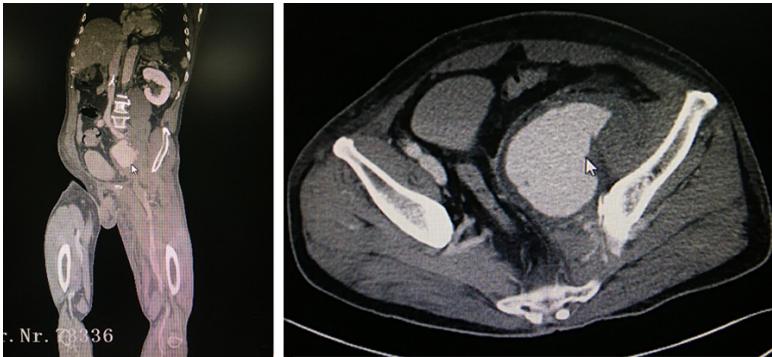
Computed tomography angiography (CTA) shows pseudoaneurysm of the left internal iliac artery. Soft-tissue mass shadows are seen anterior to the left ilium, which is filled with the contrast agent. There is no clear boundary between the soft tissue mass and internal iliac artery, and the soft tissue mass causes compression on left external iliac artery and common iliac artery.
